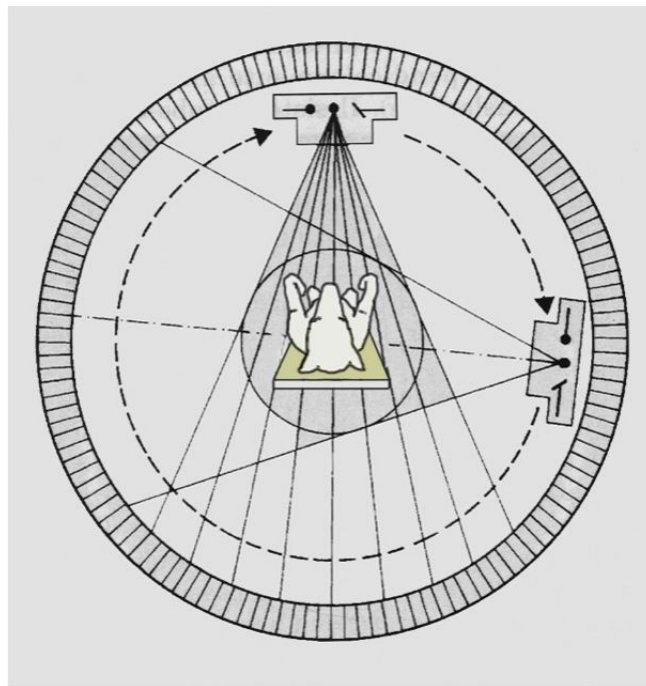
A representation of fourth generation CT scanner (Fan Beam, stationary circular detector).
